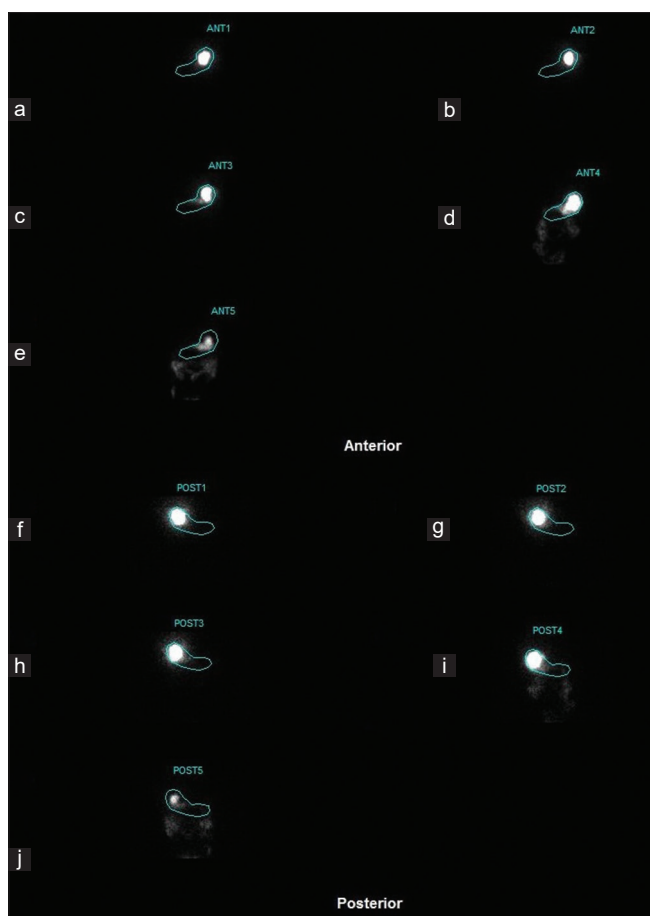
Gastric emptying scintigraphy performed in a 47-year-old male patient of type 2 diabetes mellitus of 10 years' duration. Images were acquired in anterior (a-e) and posterior (f-j) projections after the administration of radiolabeled *Idli* meal immediately, at 30 min, 1 h, 2 h, and 4 h. Entire tracer is seen in the stomach in the first images acquired immediately post meal (a and f) and is gradually noted in the intestines in the images acquired subsequently. Images at 4 h (e and j) correspond to significant tracer retention in the stomach
